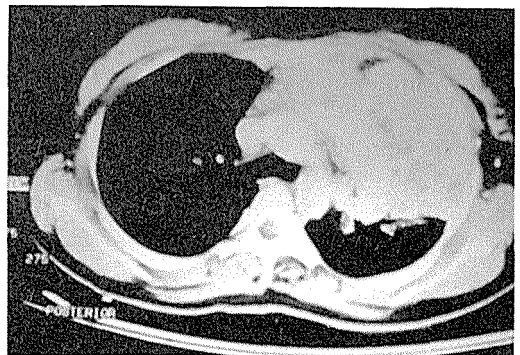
CT scan of the chest demonstrating a big mass arising from the anterior mediastinum and invading the left upper lung field.
